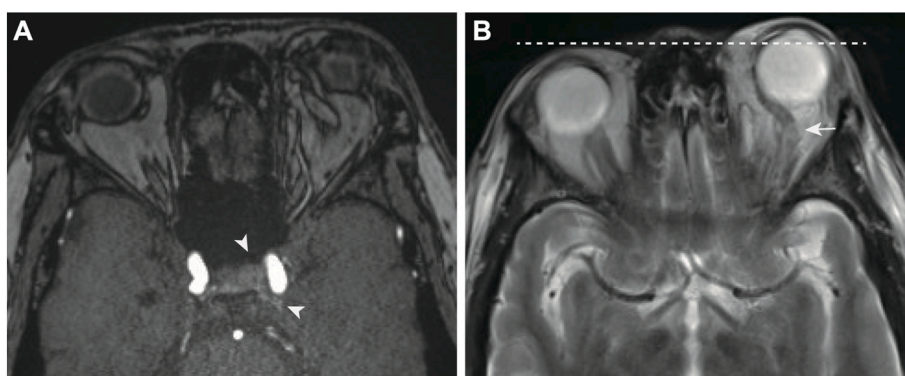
Contrast-enhanced Magnetic Resonance Imaging (MRI) when the patient experienced tinnitus after consultation. A: MR angiography revealed abnormal vascular flow around the left internal carotid artery (arrowhead). B: T2 weighted imaging showed the enlarged left superior ophthalmic vein (arrow) and left exophthalmos (dotted line). These findings are consistent with a cavernous sinus dural arteriovenous fistula (CS-DAVF).
